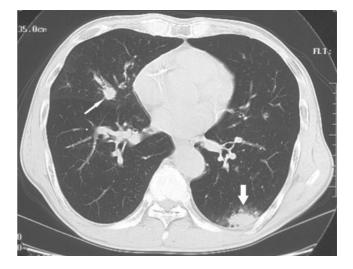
Wegener's granulomatosis in a 70-year-old woman. Thin-section CT shows a pulmonary nodule with the CT halo sign in the left lower lobe (thick arrow). Note another nodule in the right middle lobe but without surrounding ground glass opacity (thin arrow) (Courtesy of Kyung Soo Lee, MD, Samsung Medical Center, Seoul, Korea).
